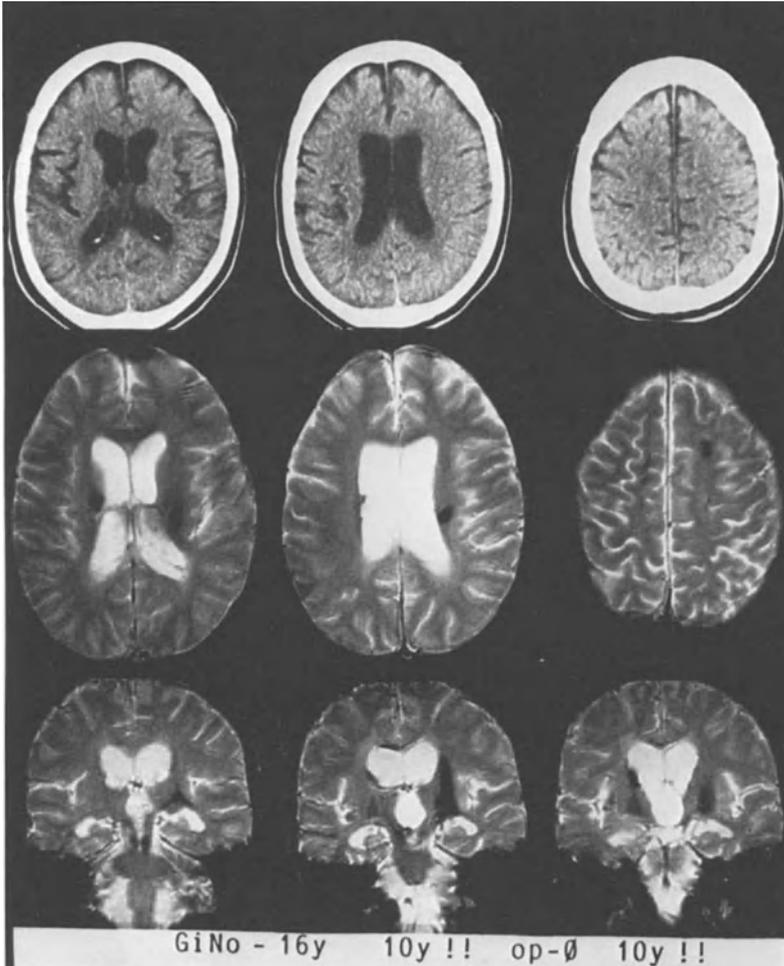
CT (above) and MRI (middle/below) 10 years after closed head injury with a persistent vegetative state. CT: Widening of external and internal cerebrospinal fluid space; doubtful hypodensity of the upper left thalamus (lower scans disclose the atrophy of the brain stem). MRI: Bilateral reduced intensities: periventricular, frontal right, basal ganglia, and brain stem (coronal sections). GiNo, initials; 16 y, age at the time of accident: 16 years; 10 y, duration of apallic syndrome; op-Ø, no neurosurgical operation; 10 y, clinical outcome after 10 years: vegetative state. EEG: since March 1978 flat beta-wave variant. (From [32])
